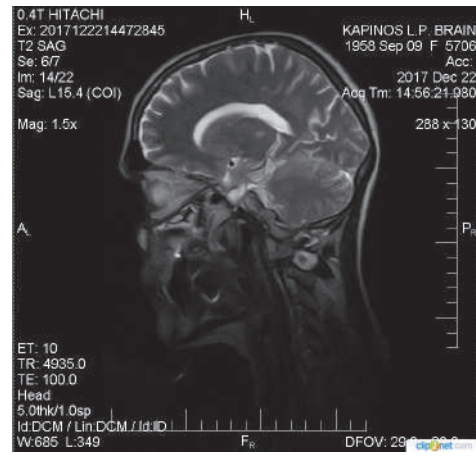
T2WI MRI of the brain of patient K.. (December 22, 2017)
